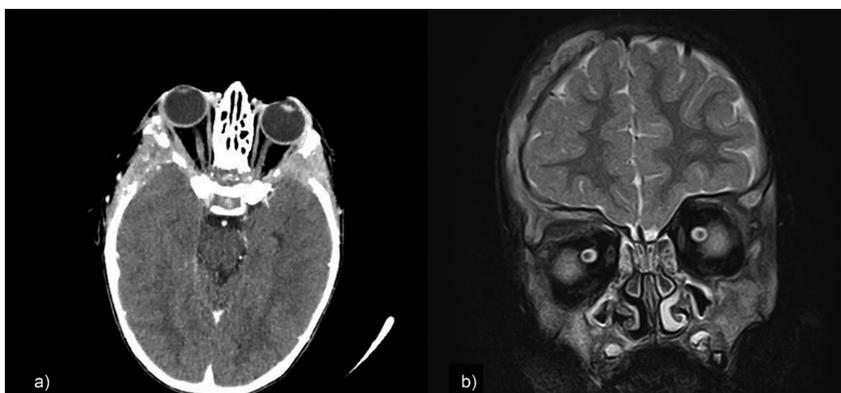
a) CE-CT axial scan revealed the presence of osteolytic lesions in the skull, causing right-side proptosis; b) Coronal T2w MRI scan indicates the involvement of the right orbital roof, along with the rest of the frontal bone with isointense osteolytic lesions.
